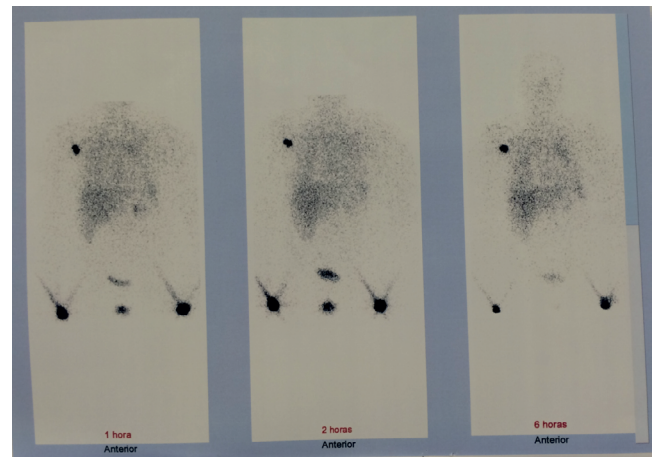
Lymphoscintigraphy of a patient with lymphedema related to breast cancer. The exam shows absence of marking of drainage lymph nodes even in the image delay of six hours and absence of dermal reflux.
